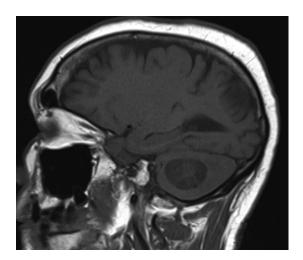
MRI sagittal view T1 image demonstrating the tumor.
